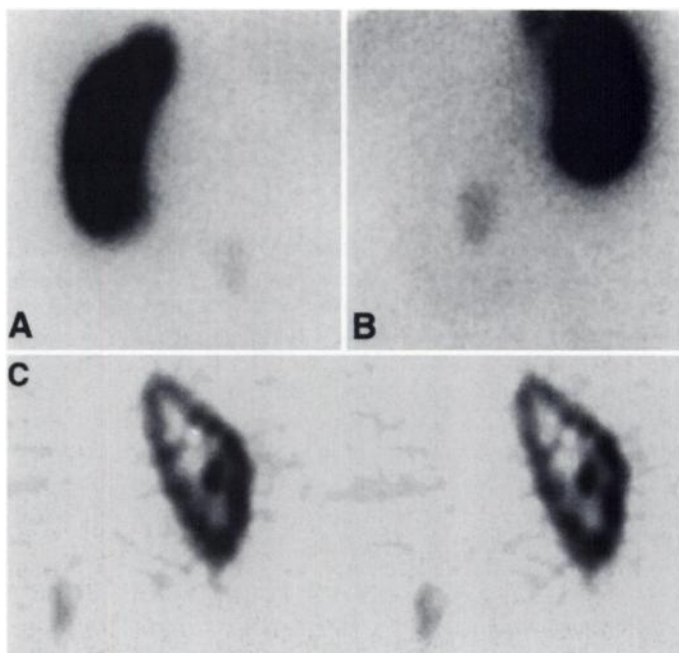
Planar images: (A) posterior; (B) anterior; (C) coronal SPECT reveal tracer localization in a small ectopic right kidney.
